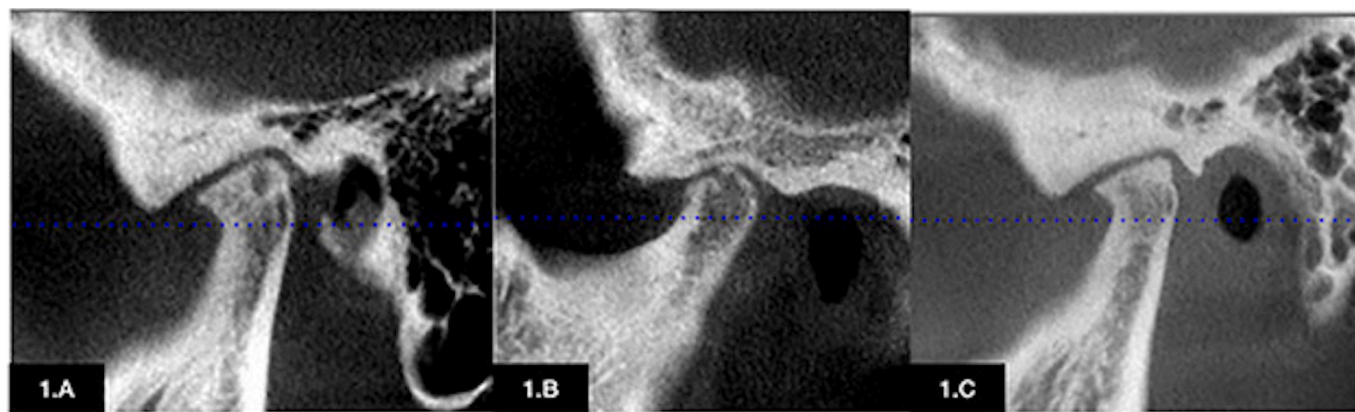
CBCT findings in degenerative joint disease in temporomandibular joints. A: presence of a subcortical cyst, osteophyte, and sclerotic articular eminence; B: condyle surface erosion; C: flattening of the condyle surface and articular eminence, condylar cortical sclerosis, and osteophyte.
